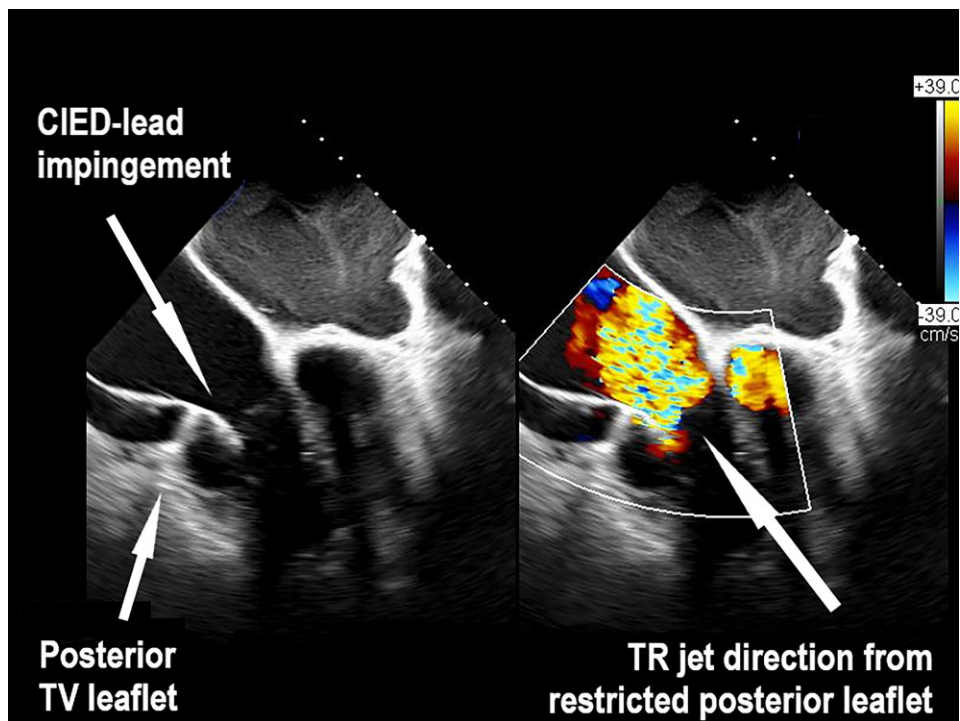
Transoesophageal echocardiogram showing tricuspid regurgitant jet direction going away from the posterior leaflet restriction by cardiac implantable electronic device-lead impingement.
